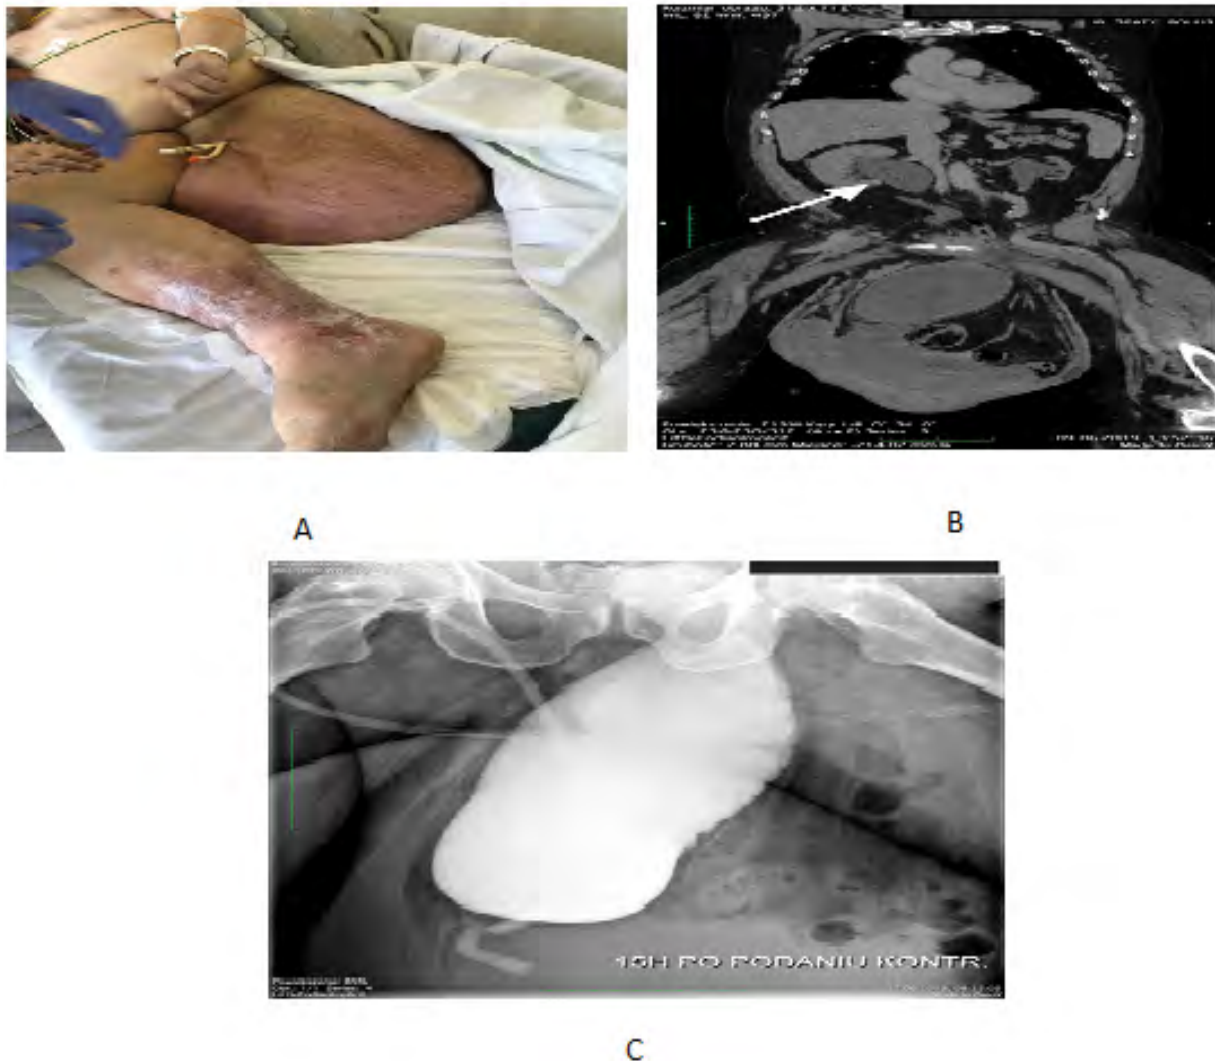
A: Left side inguinal hernia. B: CT scan revealing right hydronephrosis; involvement of urinary bladder, distal parts of both ureters and sigmoid colon in hernia sac. C: Urethrocystography which revealed urinary retention and a full dislocation of a bladder to the hernia sac.
